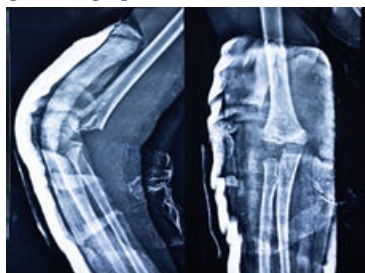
Pre-op Radiograph
